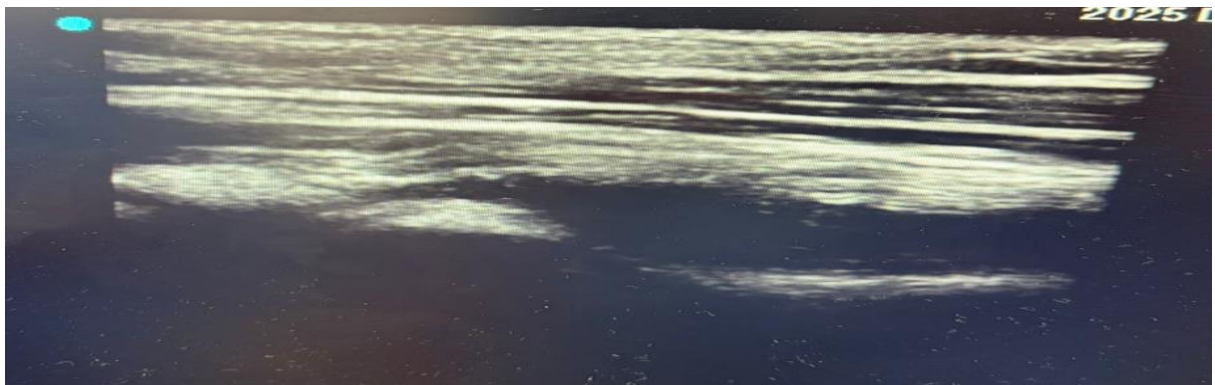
Longitudinal point-of-care ultrasound image obtained using a high-frequency linear transducer demonstrating the retained peripheral intravenous catheter fragment within a superficial forearm vein.
